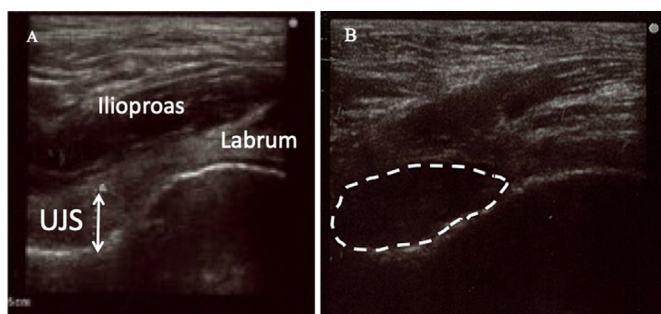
Ultrasonography findings of femoral neck
